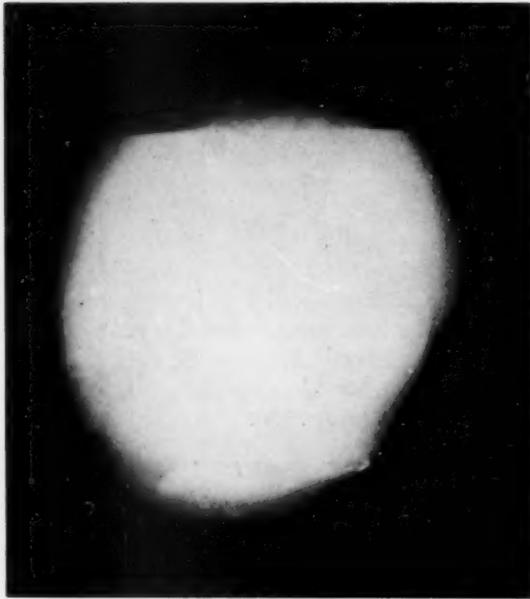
Roentgenogram of excised tumor made immediately after operation and while the tumor was still at about body temperature. Under these conditions it is possible to make out structures that did not show in roentgenograms of the chest with the tumor in situ. Note shadow of hair ball floating in aqueous fluid with its upper surface projecting into the fluid fat. Note also patches of calcification at upper and lower pole which were not seen in Figures 1 and 2.
